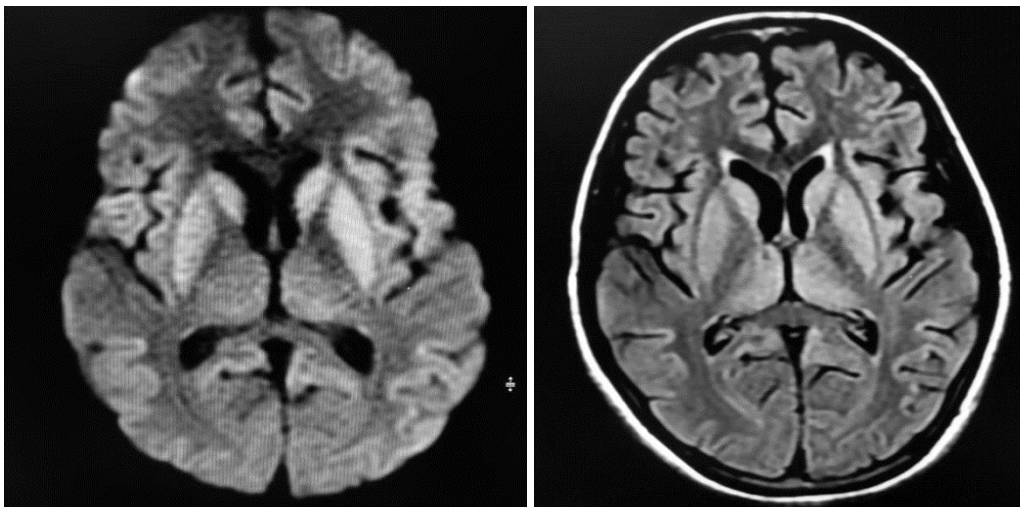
Diffusion restriction in both cerebral hemispheres in frontal, parietal occipital cortex along with diffusion restriction in the bilateral caudate nucleus, lentiform nucleus, and thalamus region with corresponding areas of hyperintensities on FLAIR.
